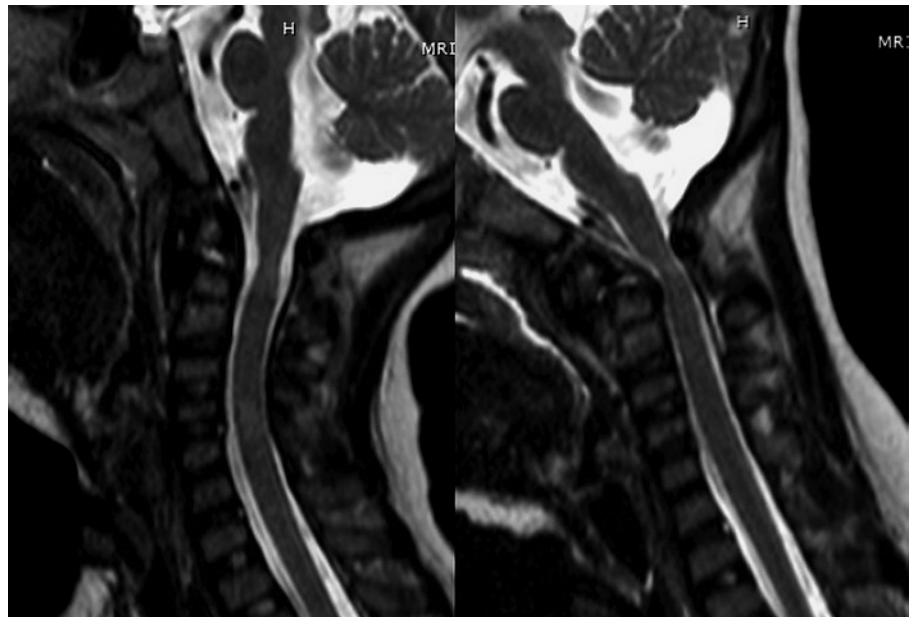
Example of Instability on dynamic imaging. The left-sided image is a T2-weighted MRI in the sagittal plane with the head in a neutral position. The right-sided image is the head now in flexion. Note the movement of C1, dens fracture, and compression of the neuraxis.
